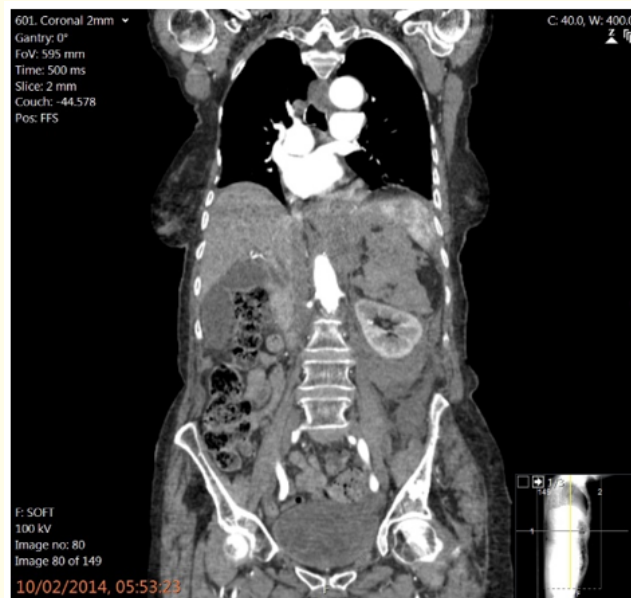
CT coronal view showing a large retroperitoneal haematoma (white arrow) and causing displacement of the spleen and diaphragm.
